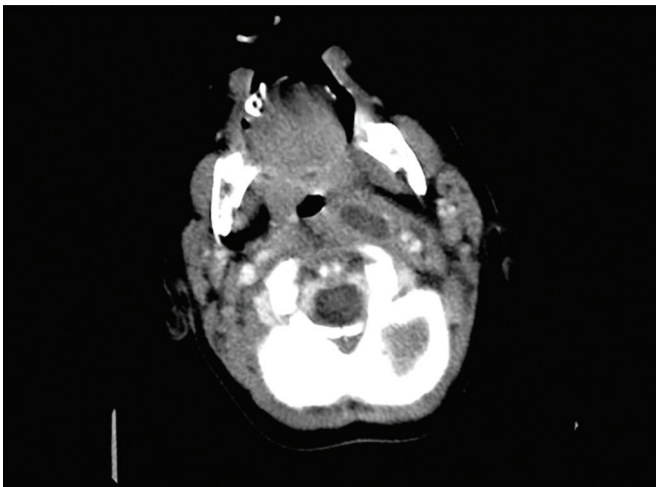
Axial computed tomographic image of a left parapharyngeal space infection in a 1-year-old child.
